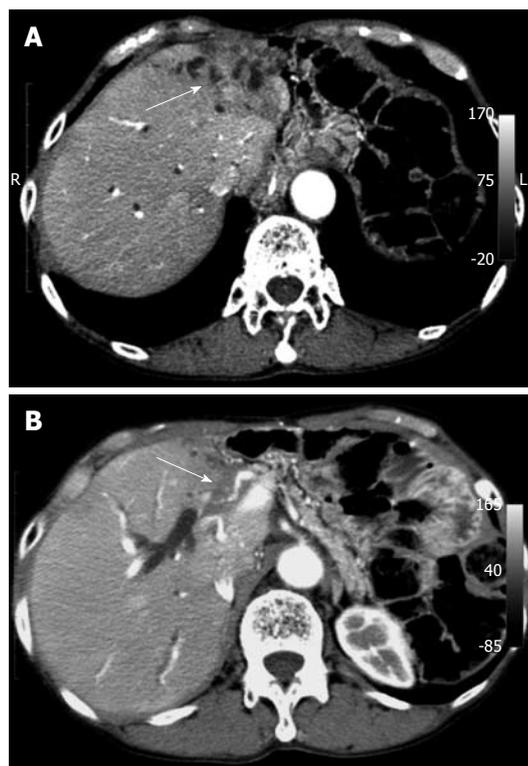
Abdominal computed tomography. A: Computed tomography showing a tumor in the left lobe of the liver (arrow); B: This tumor invading the proper hepatic artery (arrow).
